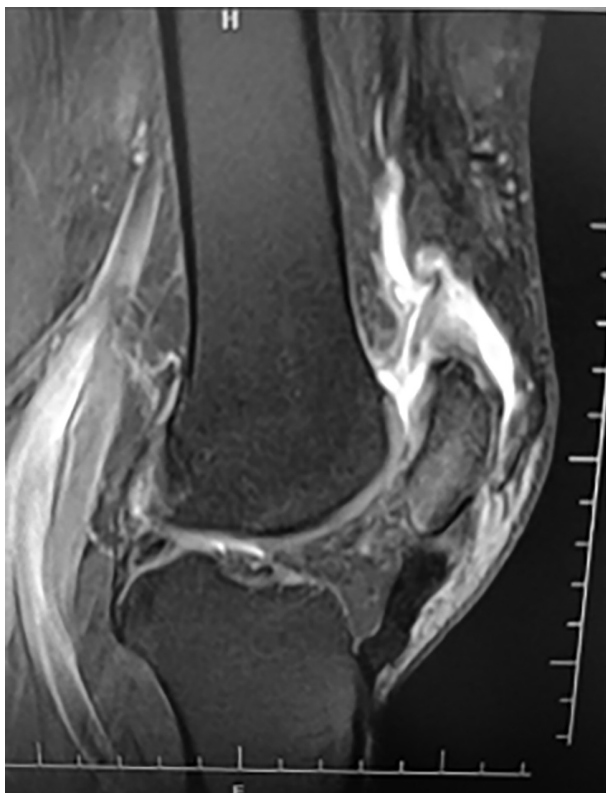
Sagittal MRI of the right knee in T2 sequence, showing a continuity lesion at the insertion level of the quadriceps tendon in the superior pole of the patellar tendon.
